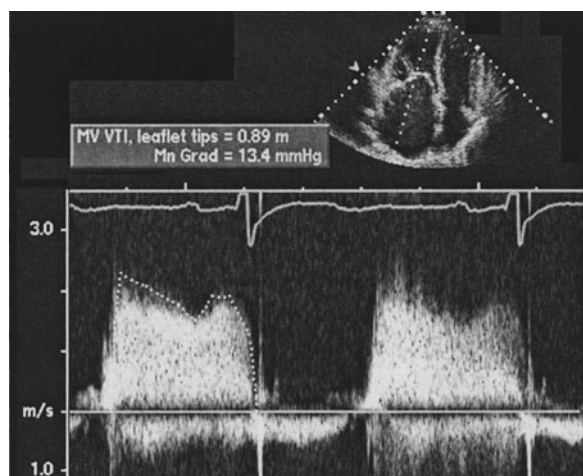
Continuous-wave Doppler recording of the mitral gradient in a patient with severe mitral stenosis (MS). Note the high velocity (≥ 2 m/s) with a mean gradient of more than 13 mm Hg. Note also the flat slope of deceleration of the early diastolic velocity consistent with severe MS.
